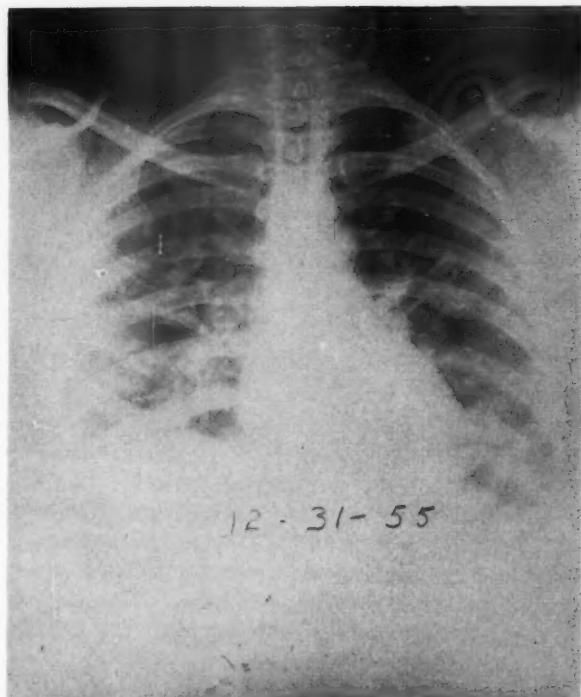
Chest roentgenogram, posteroanterior view, December 31, 1955.
